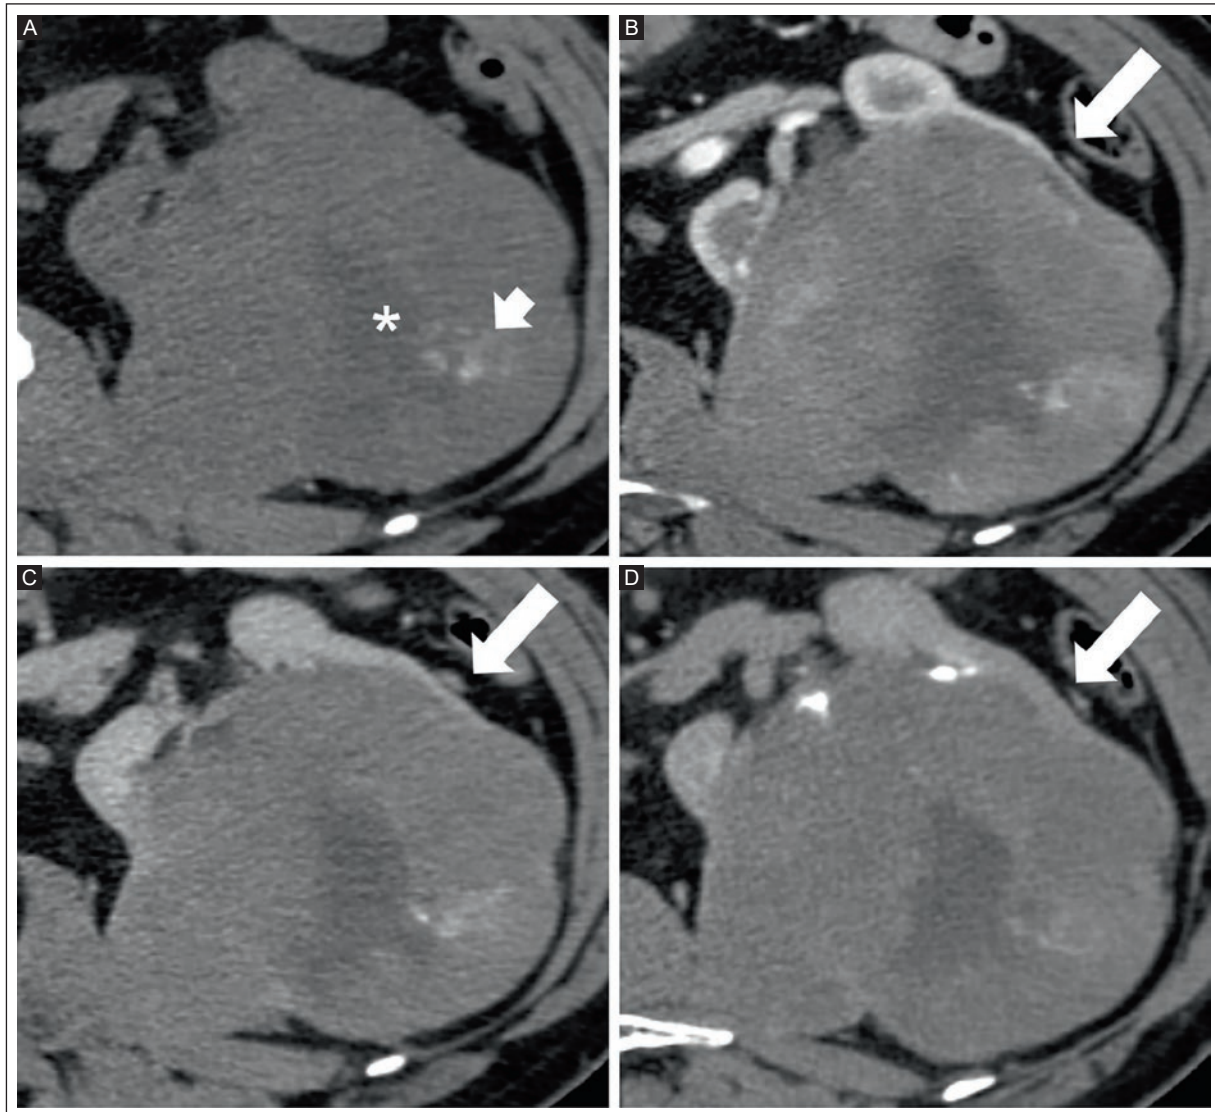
CT of a 74-year-old man diagnosed with a left-kidney chrCC. A: non-contrast CT shows an expansile heterogeneous lesion with a necrotic central area (asterisk) and calcifications (arrow). B: arterial phase, C: nephrographic phase, and D: excretory phase show minimal peripheral enhancement explained by its hypovascularity (arrows).
